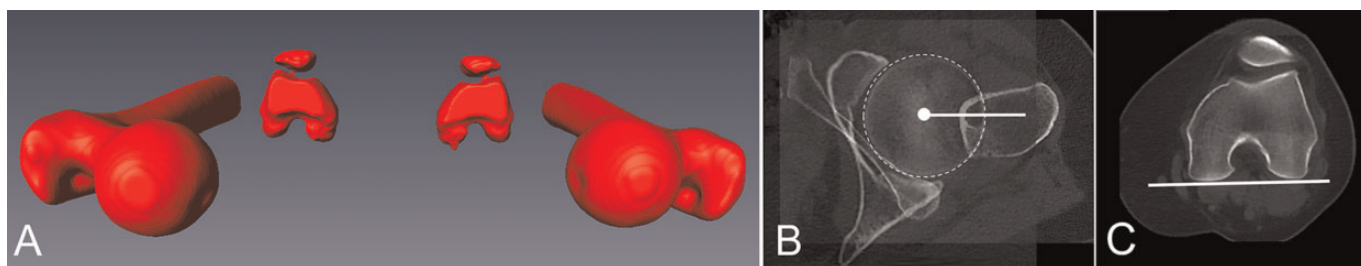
(A) A 3-dimensional model of the bilateral femur and (B, C) axial computed tomography images of the hip and posterior femoral condyle in a 26-year-old man with absolute femoral retroversion. (B) The femoral head center (white dot) was connected with the center of the femoral shaft on the level of the lesser trochanter to define the proximal landmarks. (C) The posterior condyles were connected with a line for the distal landmarks.
